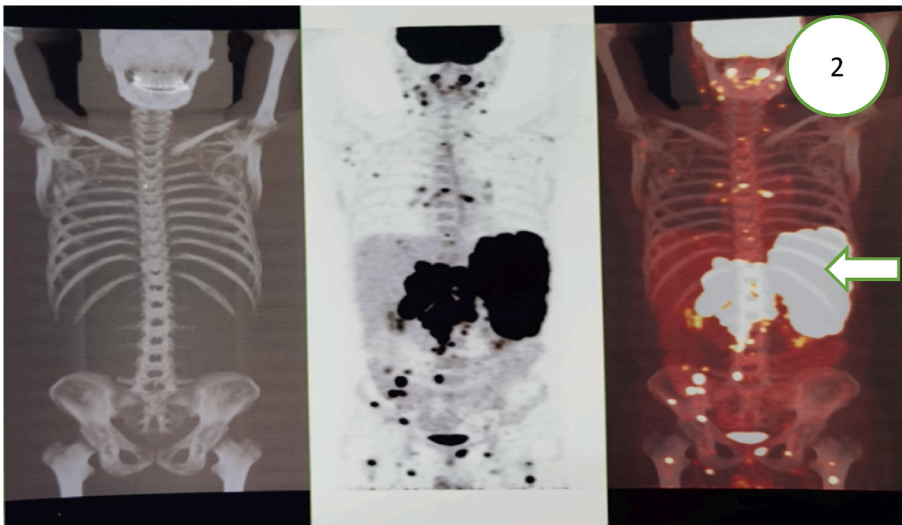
PET-CT examination of splenomegaly, multiple lymph nodes at multiple sites and multiple foci of metabolic hyperplasia, with consideration of malignancy and possible lymphoma infiltration.
